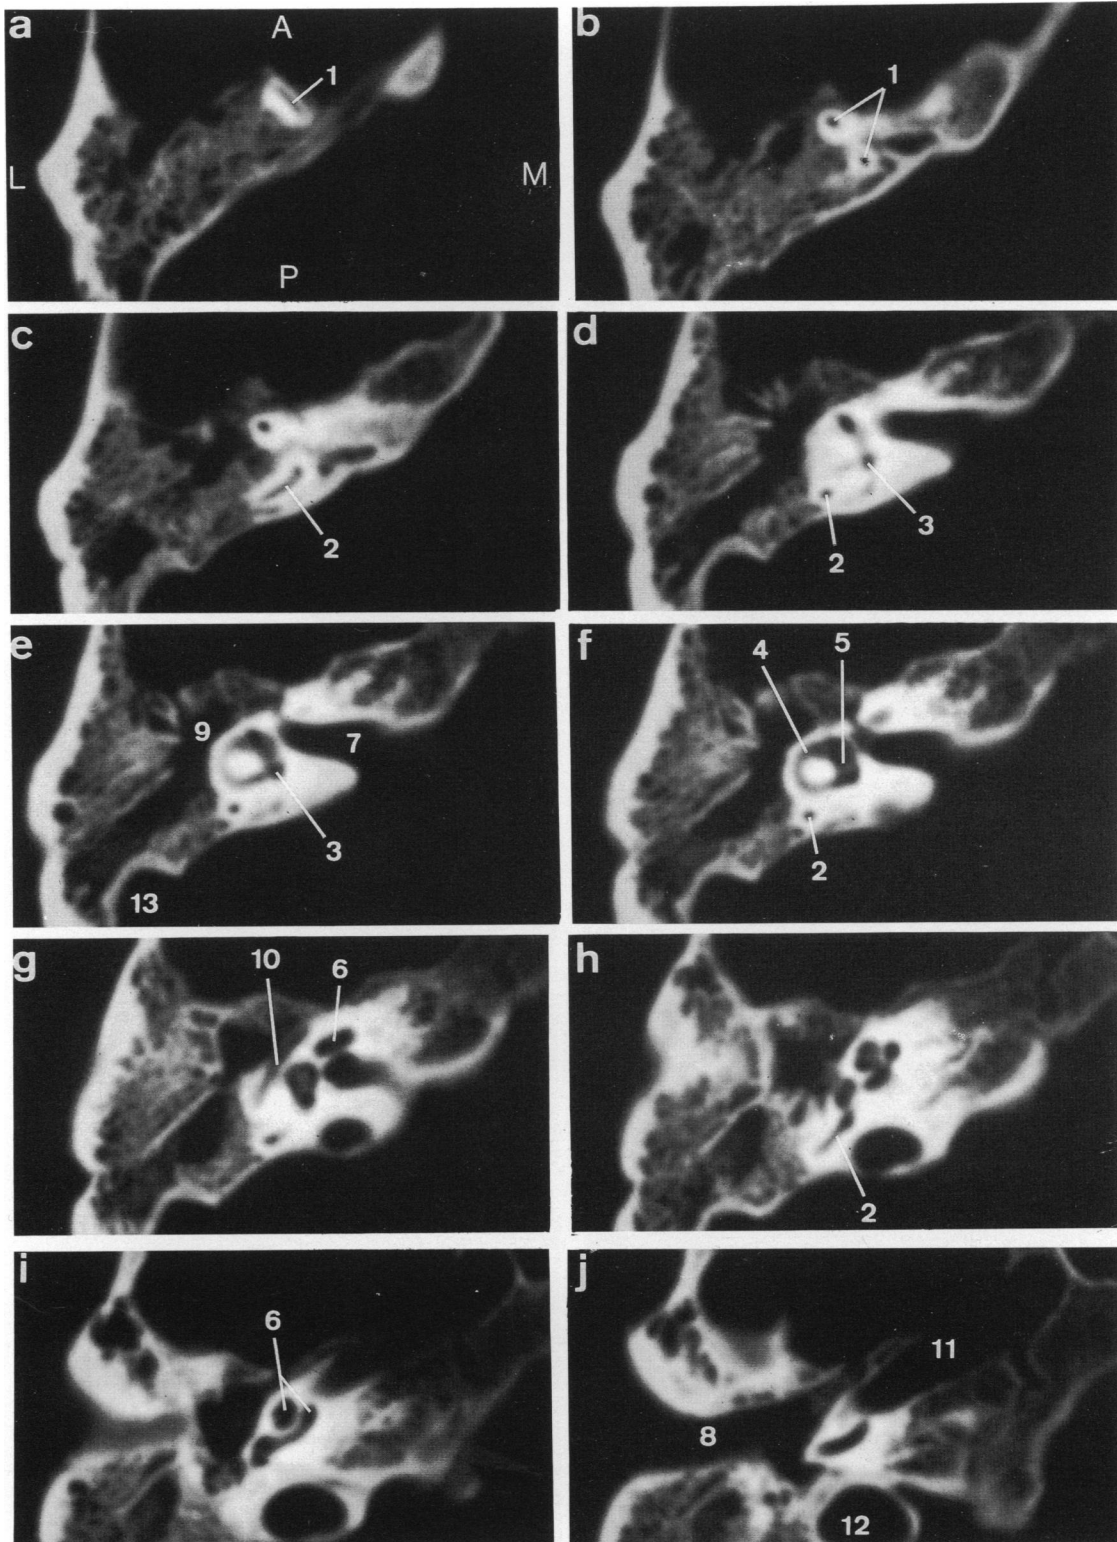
Transverse CT scans of the temporal bone of a dry human skull going from superior to inferior, showing the labyrinth from the superior tip of the anterior semicircular canal (*a*: 1) to the basal turn of the cochlea (*j*). All scans are made contiguously, except (*e*) which is overlapping with (*d*) and (*f*). A, anterior; P, posterior; L, lateral; M, medial. 1, anterior semicircular canal; 2, posterior semicircular canal; 3, common crus; 4, lateral semicircular canal; 5, vestibule; 6, cochlea; 7, internal acoustic meatus; 8, external acoustic meatus; 9, tympanic cavity; 10, facial canal; 11, carotid canal; 12, jugular fossa; 13, sulcus for sigmoid sinus.
